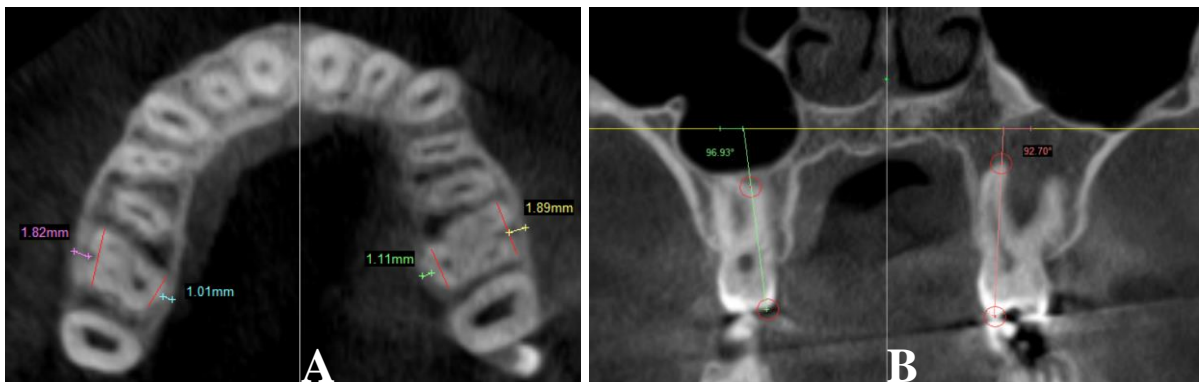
CBCT measurements. A; Buccal and palatal alveolar bone width measurements on axial view. B; Molar angulation measurements on coronal view.
